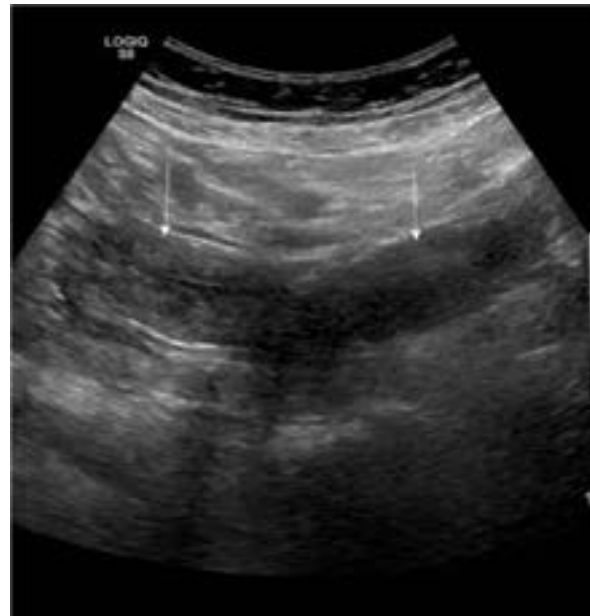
Ultrasonography image demonstrating two uterine cavities (white arrows).
